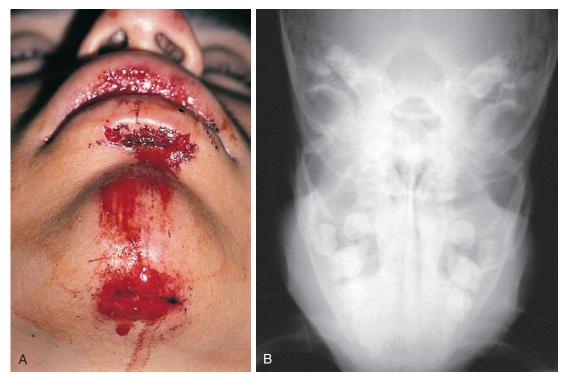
A, This boy incurred a forced occlusion injury when hit by a car and thrown from his bike. Note the chin laceration and through-and-through lip laceration. B, He also had bilateral condylar neck fractures of the mandible. In this radiograph the condyles bend inward at nearly 90 degrees above the fracture lines.
